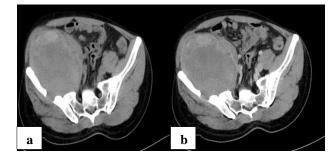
(a) Plain and b) post contrast CT images show a large hyperdense minimally enhancing lesion with few fluid-fluid levels within centered in the right iliopsoas muscle causing erosions of the right iliac bone.
